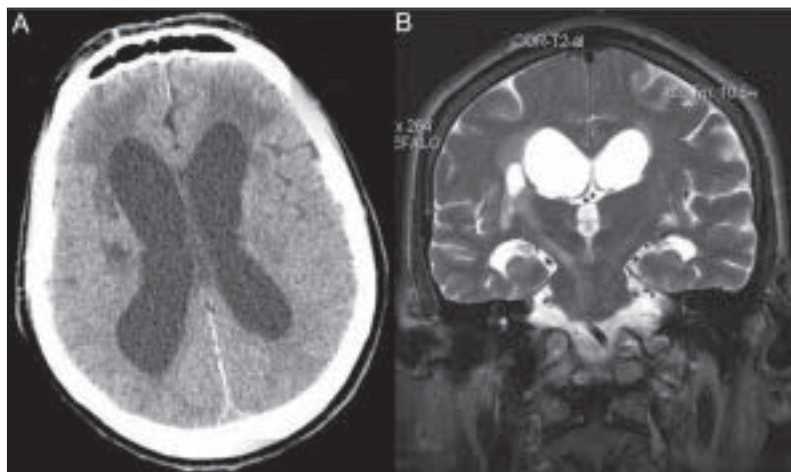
Ischemic stroke in a patient with *Cryptococcus neoformans* meningitis. CT scan (A) and brain MRI T2-weighted sequence (B)
